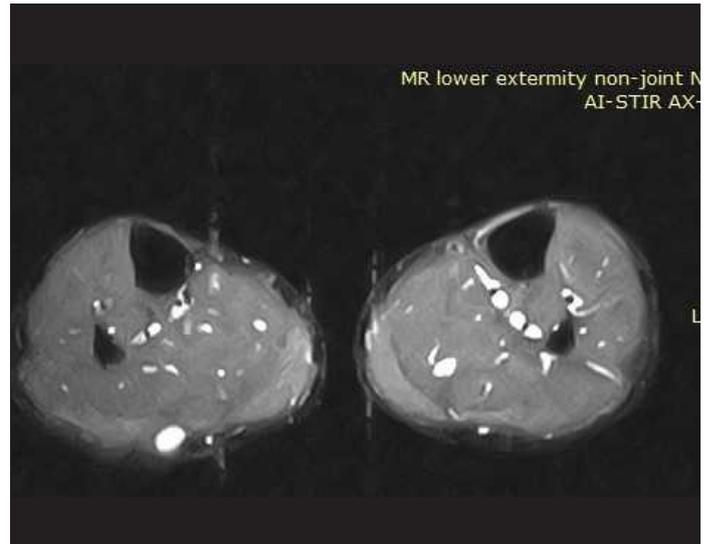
MRI revealed a well-defined, oval mass in the posterior aspect of the right leg.
